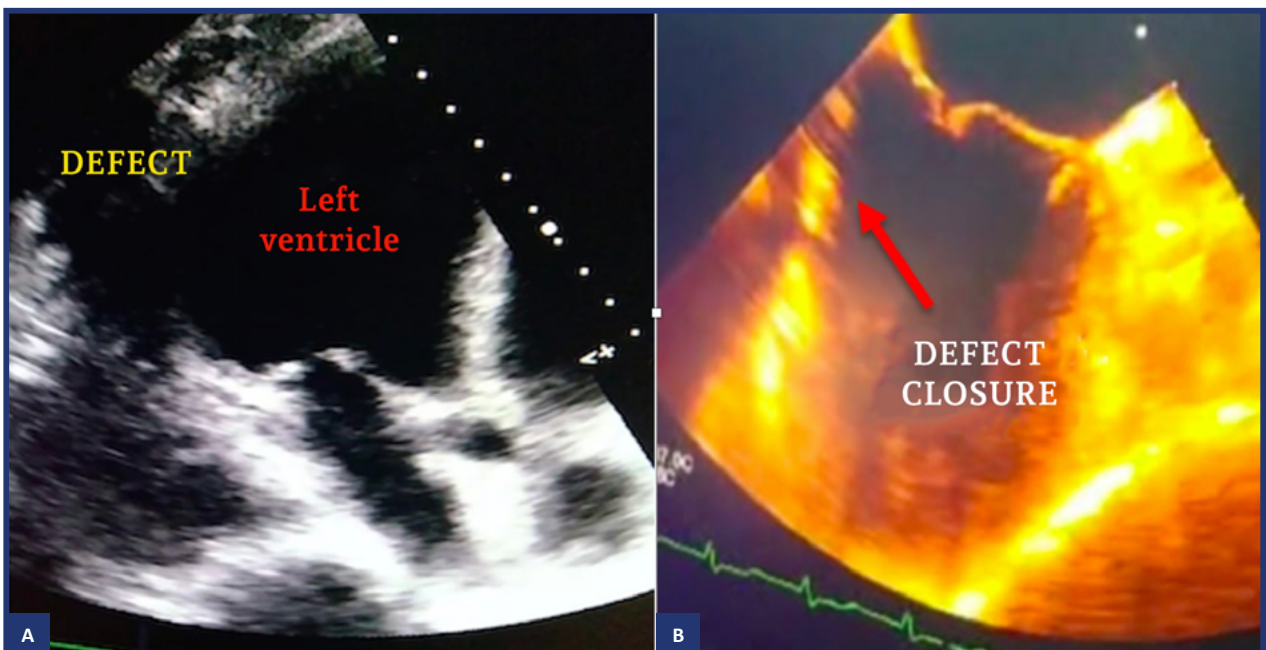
Transesophageal echocardiogram before (A) and after surgical repair (B).
